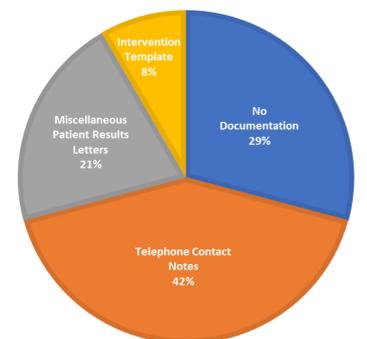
Post-intervention CT Results Reporting
